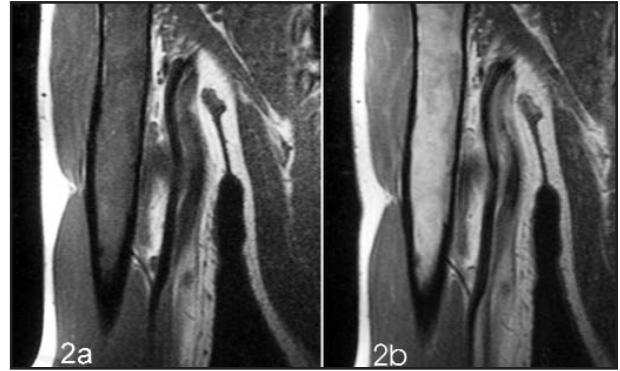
The fibrous dysplasia on coronal T1-weighted sequences shows a heterogeneous signal intensity similar to muscle on the pre-contrast sequence (a) and heterogeneous enhancement on the post-contrast sequence (b).
